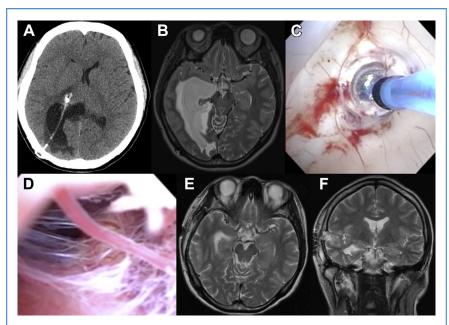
Case 1. (A) Preoperative computed tomography scan showing right thalamic hemorrhage owing to migration of a ventriculoperitoneal shunt tube and enlargement of the trigone of the right lateral ventricle. (B) Preoperative magnetic resonance imaging showing right isolated lateral ventricle with perifocal edema. (C and D) Intraoperative endoscopic pictures showing fenestration of the mesial temporal wall with a balloon catheter to the basal cistern. (E and F) Postoperative magnetic resonance imaging demonstrating improvement of isolated lateral ventricle and perifocal edema.
